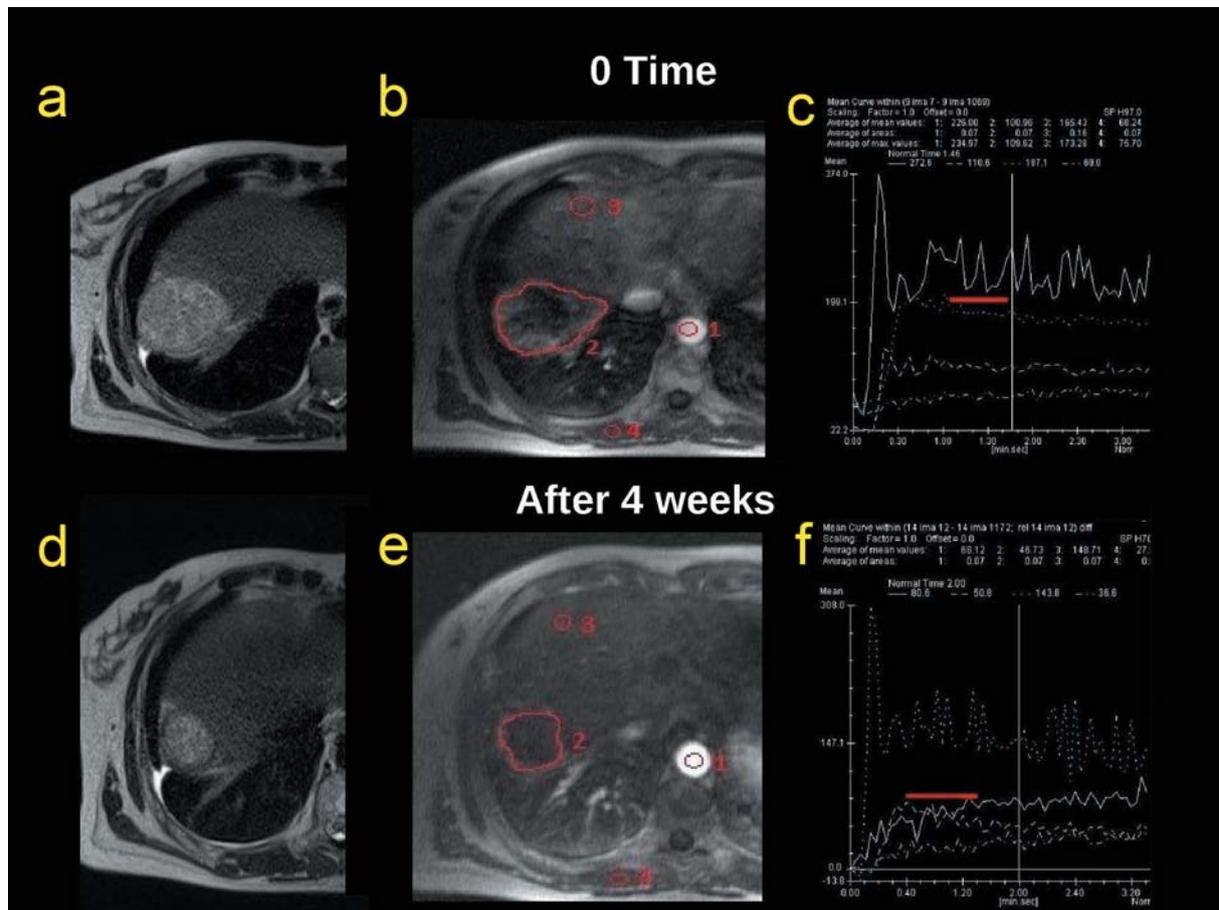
MRI of a female patient showing a metastatic lesion in the VII-VIII segment before treatment (a-c) and after four weeks of treatment (d-f). a: T2-weighted sequences show a inhomogeneous hyperintense mass of 4 cm in maximum diameter. b: Qualitative assessment of perfusion images show the same lesion as a hypointense zone with peripheral vascularization; regions of interest were plotted on the lesion, abdominal aorta, liver and muscle. c: Semi-quantitative analysis using intensity/time curves highlights the grade of vascularization of the lesion. d: T2-weighted sequences showing a slight dimensional reduction of approximately 0.5 cm of the metastatic lesion after four weeks of treatment. e: Qualitative assessment using perfusion images depicting the reduction of vascularization of the lesion; regions of interest were plotted on the metastasis, aorta, liver and muscle. f: Semi-quantitative approach revealing the lesion's behavior compared to the aorta, liver and muscle. The semi-quantitative analysis by means of intensity/time curves adds important functional information to morphological criteria, which only indicates dimensional reduction; the former highlights the reduction of neoangiogenesis and therefore the response to anti-angiogenic therapy.
